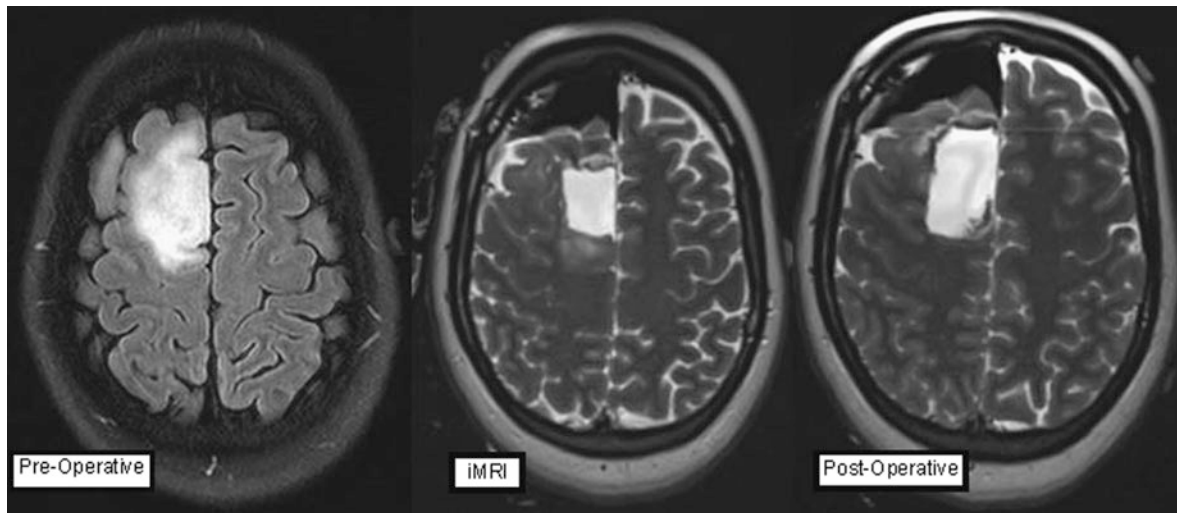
Sample glioma case. (a) Preoperative MRI (*left*) of right frontal anaplastic oligodendroglioma prior to surgery. (b) ioMRI (*middle*) after initial resection demonstrated residual tumor at the posterior margin of the resection cavity which prompted further resection of tumor. (c) Postoperative MRI (*right*) demonstrating resection of the residual tumor identified on ioMRI
